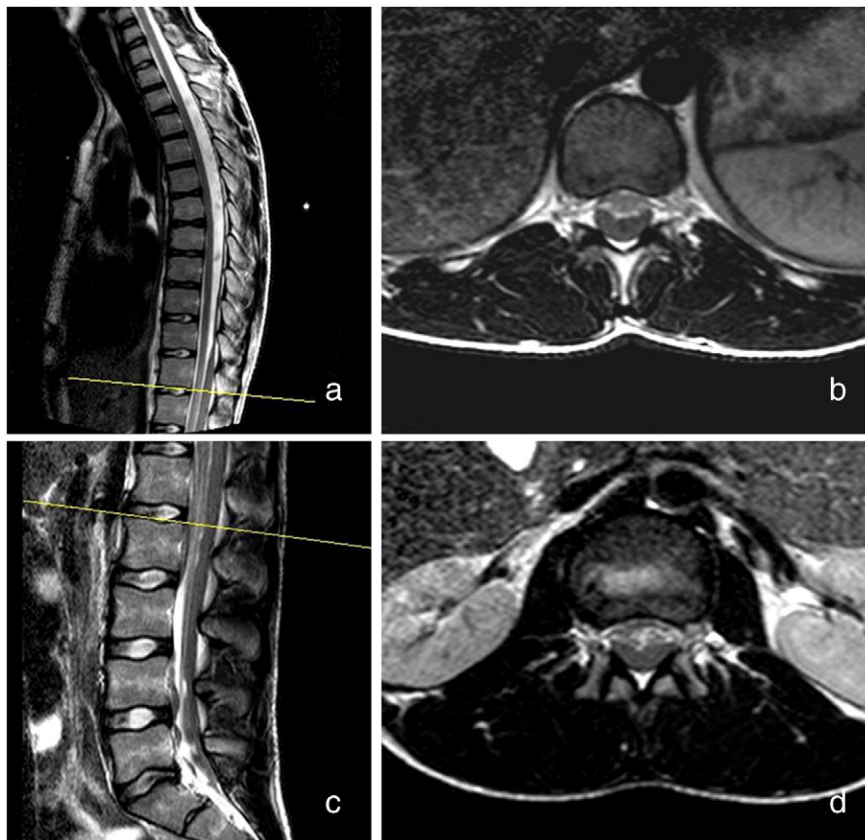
a to d, Spinal MR images at 48 hours showing the presence of spinal SDH. a and b, T2 sagittal and axial MR images displaying an intradural hypointensity originating from the T10-11 level, filling the canal diffusely and having a thin CSF column between itself and the neural elements. This appearance was diagnosed as acute spinal subdural hemorrhage. c and d, Lumbar sagittal and axial T2 MR images.
